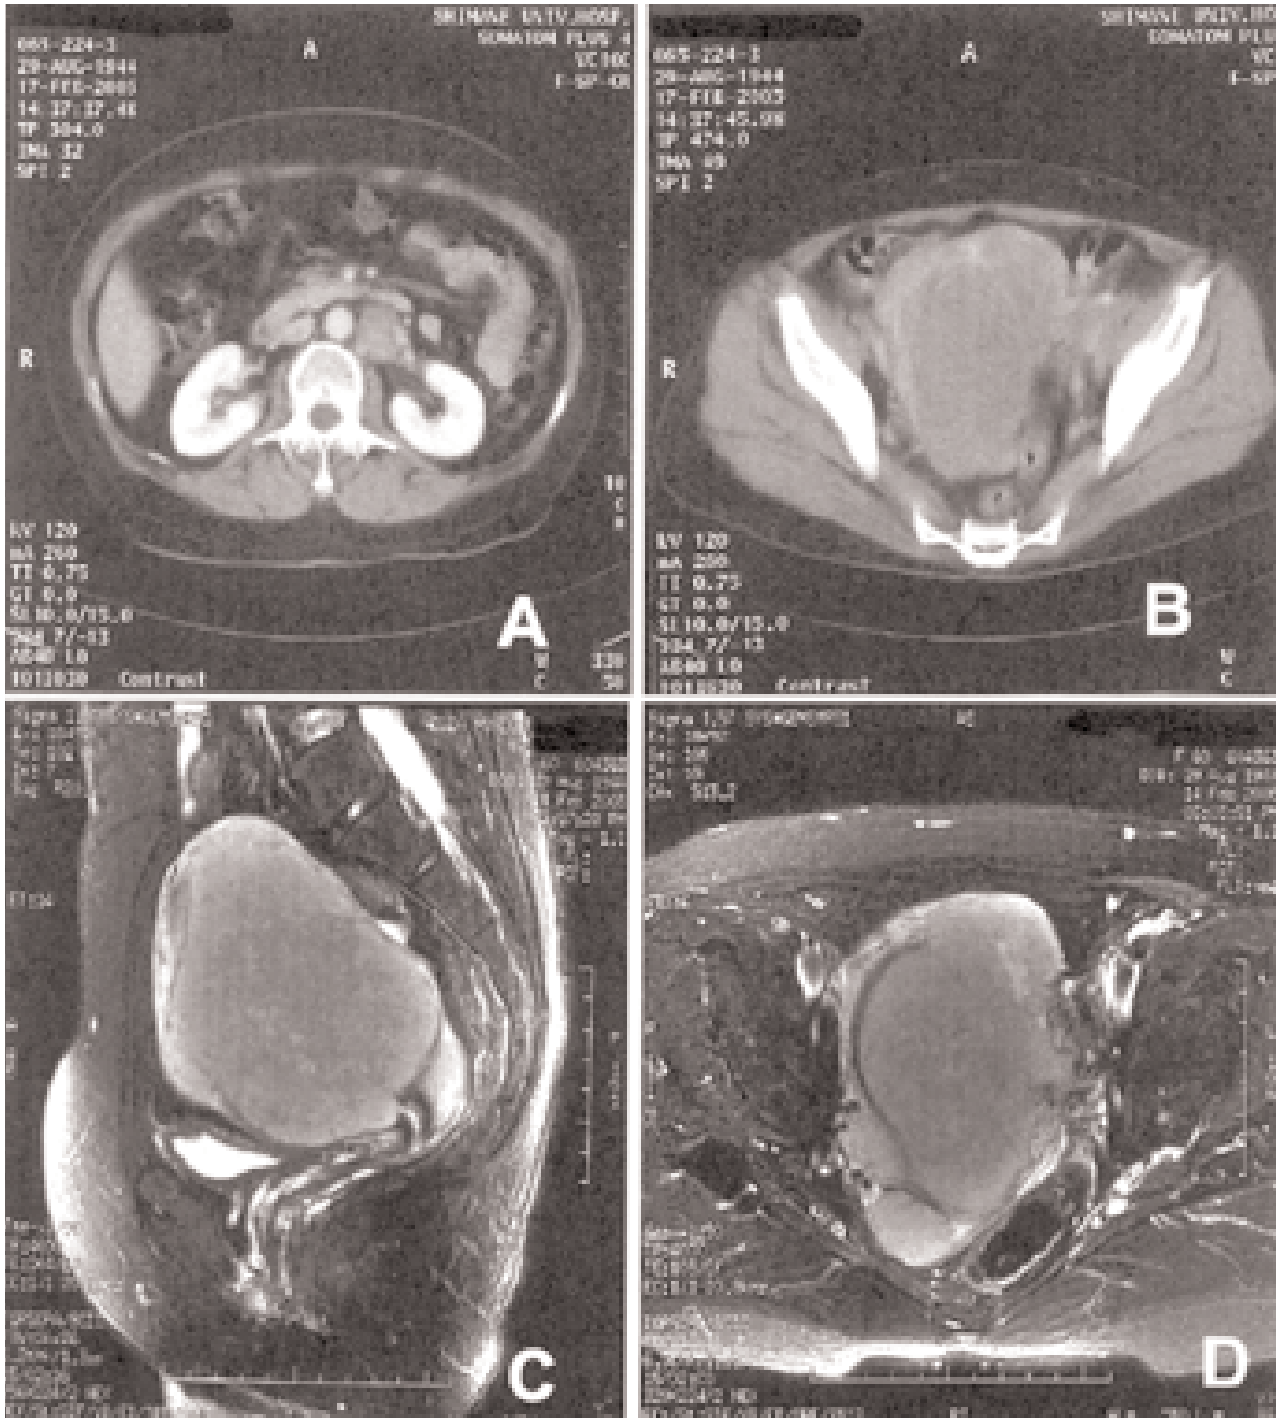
A/B) CT showing a homogeneous hyperdense mass in the abdomen arising from the pelvis and enlarged paraortic lymph nodes. C) MRI, a hypodense mass on T1-weighted images D) MRI, a hyperdense mass on T2-weighted images.
